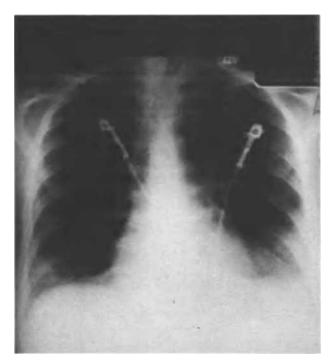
Chest radiograph (taken later the same day) showing a left basal pulmonary infiltrate and effusion, which was associated with fever, pleuritic pain, and a pleural rub
